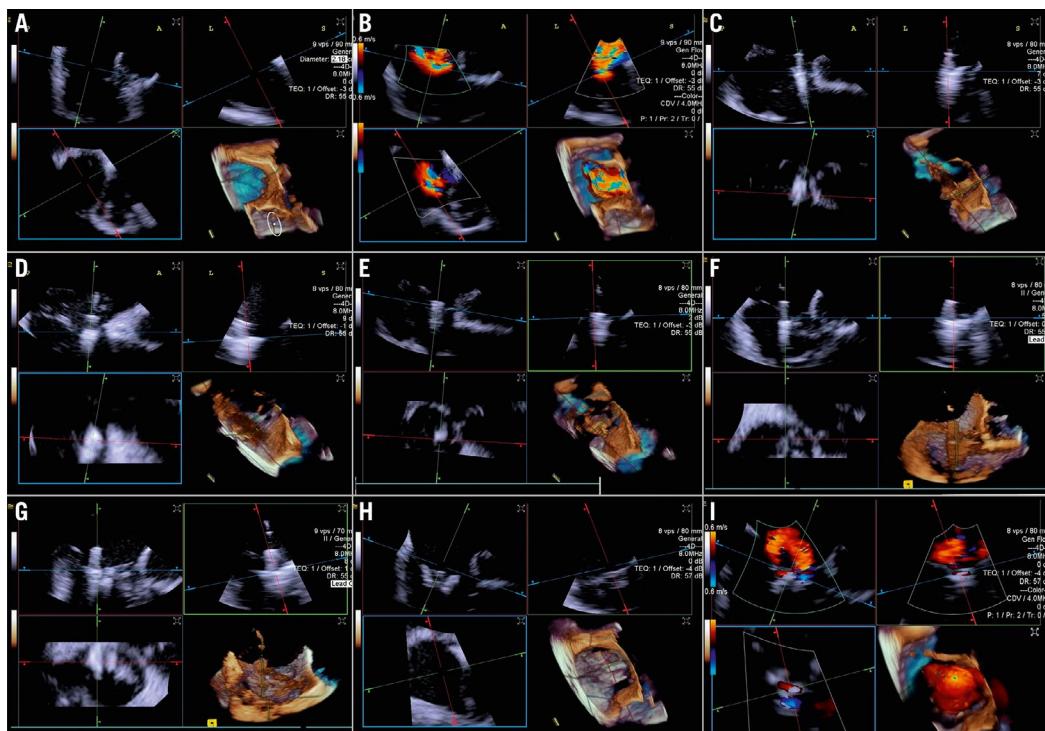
Three-dimensional ICE-guided tricuspid transcatheater edge-to-edge repair. A) 3D MPR ICE imaging planes with posterior and anterior leaflets in the TV home view (top left), septal leaflet and anterior/lateral grasping view (top right). The blue plane (bottom left) represents the short-axis (atrial en face) view of the TV leaflets. Finally, the corresponding 3D volume (bottom right; the aorta is at 5 o'clock). B) 3D colour MPR ICE imaging shows severe tricuspid regurgitation, allowing assessment of the number of regurgitation jets and jet location. C-E) The first device is advanced under the tricuspid valve. Clip orientation is optimised to be orthogonal to the coaptation line while the clip position is fine-tuned to the target location, and independent leaflet grasping is performed. F) 3D MPR assessment of second device orientation and location. G) 3D MPR assessment of third device orientation and location. H, I) 3D MPR and colour-flow Doppler final assessment of the devices. 3D: three-dimensional; ICE: intracardiac echocardiography; MPR: multiplanar reconstruction; TV: tricuspid valve
